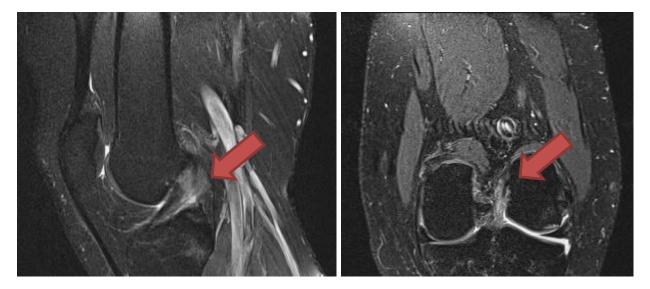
MRI of knee, SAG proton density (PD) weighted images. Partial lesion of ACL Gr. II.
